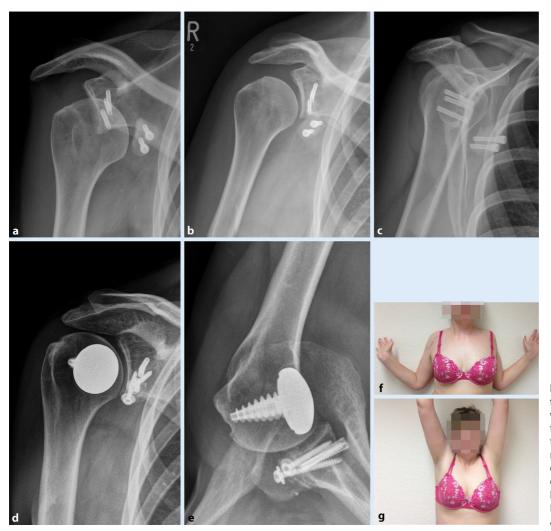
◄ a-c Traumatic fall again 6 months later with anterior luxation of the head and redislocation of the graft. d-g Xray and outcome after open re-refixation of graft (second Eden–Hybinette) + Hemicap for Hill–Sachs lesion after a renewed recurrence
